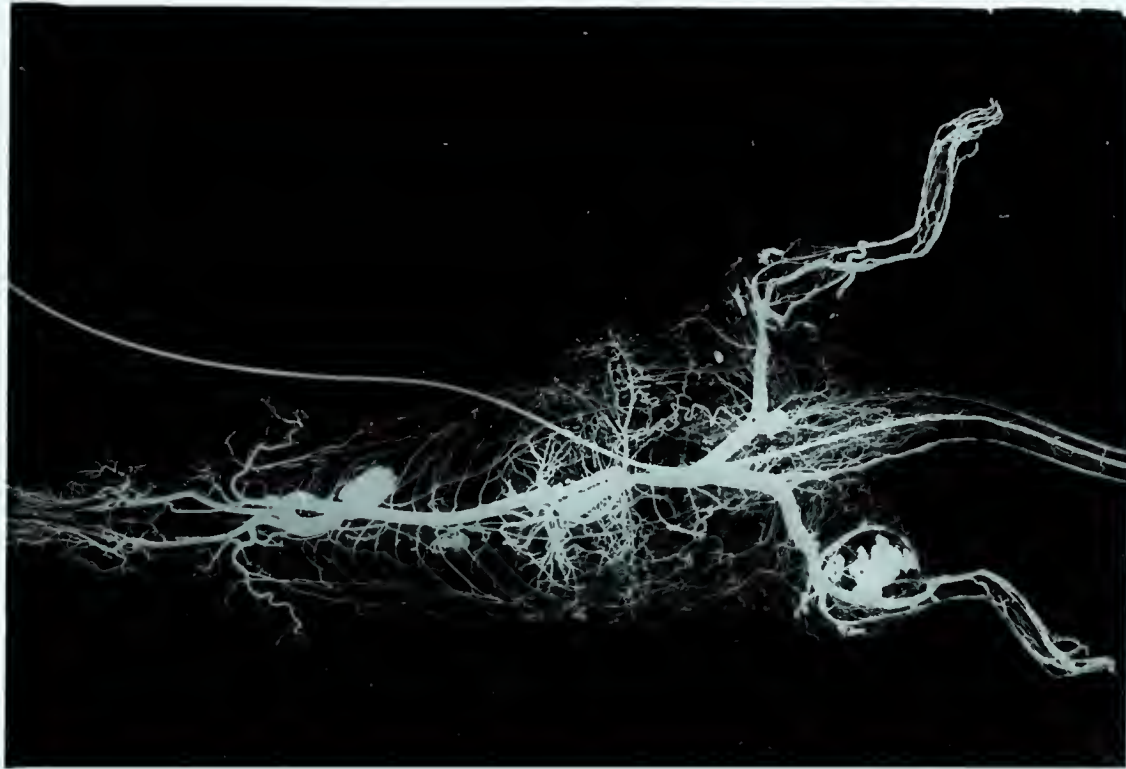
Radiograph of the hind limbs following the infusion of 5.0 ml. of metallic mercury into the abdominal aorta.
